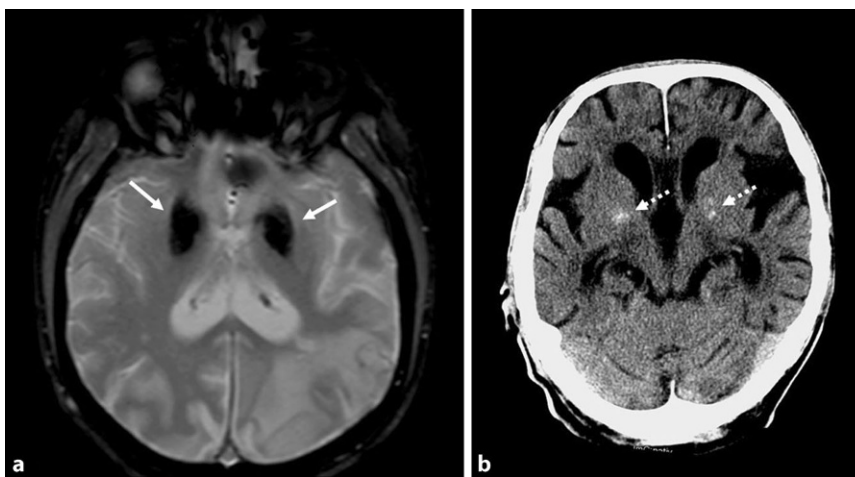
▲ a) Magnetic resonance imaging (MRI) of a 47-year-old patient with Down syndrome and structural focal epilepsy after ischemic infarction in the territory of the left middle cerebral artery. Note the generalized atrophy and the bilateral MRI hypointense signals in the basal ganglia (white arrows), indicating calcification. b) Computed tomography scan of a 65-year-old patient with dementia and epilepsy. The generalized atrophy and hyperdense areas (dashed white arrows) indicate bilateral basal ganglia calcification
